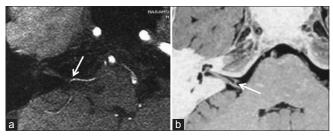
Case 1 (a) Axial enhanced magnetic resonance imaging demonstrating the right anterior inferior cerebellar artery (arrow) at the distal portion of the 7th and 8th cranial nerve complex, (b) axial T2 reverse magnetic resonance imaging showing the right anterior inferior cerebellar artery (arrow) between the 7th and 8th cranial nerve
